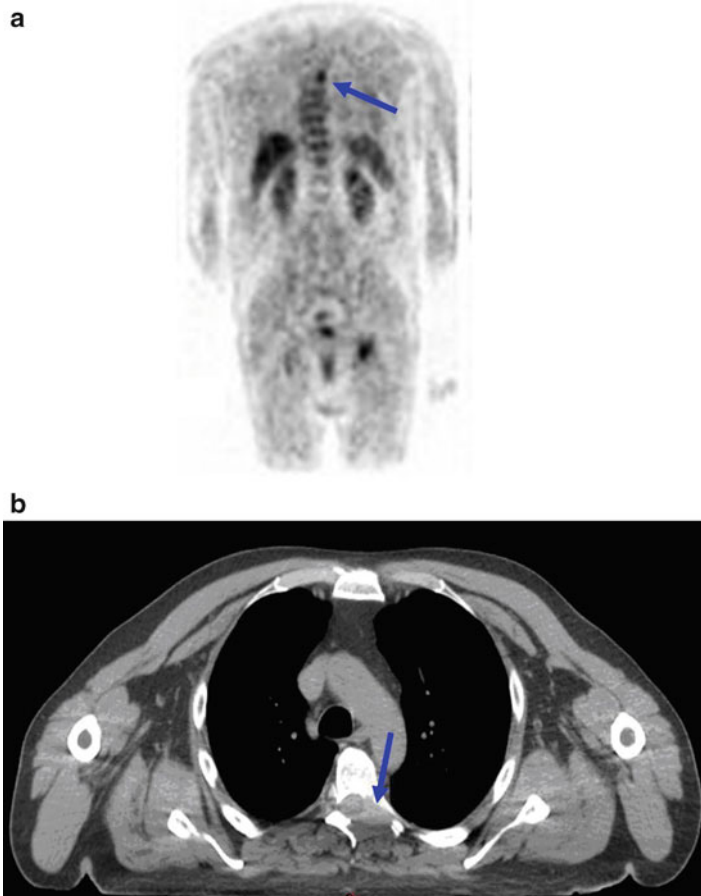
A 60 year old male with known lung cancer developed left sided mid-thoracic back pain and paraesthesiae with dermatomal radiation around the chest wall to a level just below the left nipple. (a) Anterior view of a coronal PET section through thoracic spine showing focal uptake in the left side of the vertebral column. (b) Axial CT confirming a destructive bone metastasis in the region of the left T5-6 intervertebral foramen involving the exiting T5 nerve root and accounting for the patient's neuropathic bone pain. He was treated with palliative radiotherapy to this site
